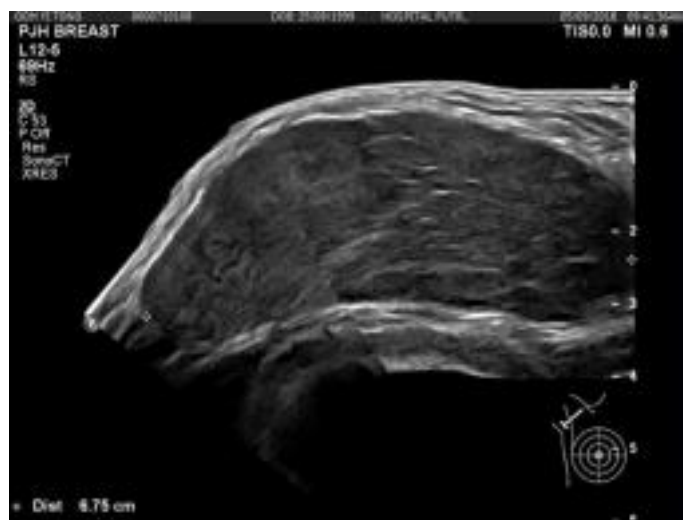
ultrasound image of right axilla
